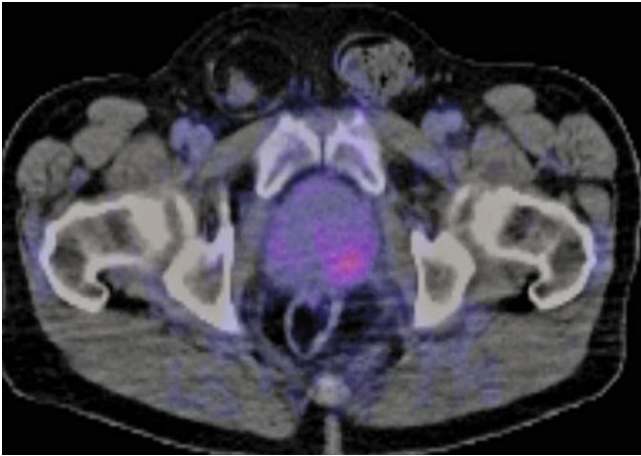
Peripheral FDG uptake within the prostate. Subsequent PSA and biopsy were indicative of prostate cancer
